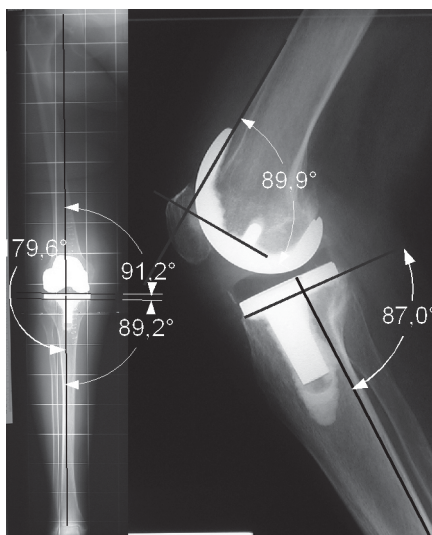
Axial alignment of the prosthesis was evaluated using standardized pre- and postoperative full-length weight-bearing radiographs.
